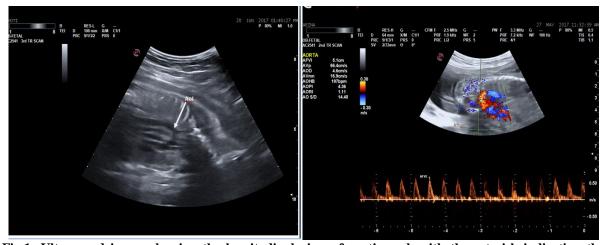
Ultrasound image showing the longitudinal view of aortic arch with the asterisk indicating the position of Aortic isthmus just distal to the origin of left subclavian artery. Fig.2: Ultrasound image showing the normal pulsed Doppler waveforms of Aortic Isthmus with antegrade diastolic flow.
